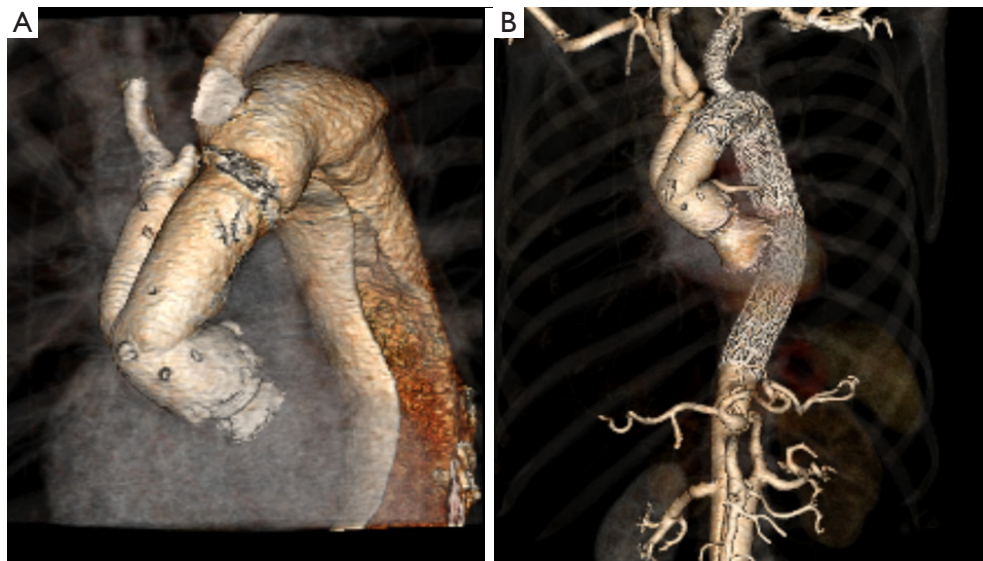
Three-dimensional CTA-reconstruction of a patient managed with a zone 2 arch replacement for type A aortic dissection (A). Due to progressive post-dissection dilatation completion TEVAR was conducted with a GORE TBE, extended with a GORE CTAG to complete the repair and induce further aortic remodeling (B). CTA, computed tomography angiography; TEVAR, thoracic endovascular aortic repair.
